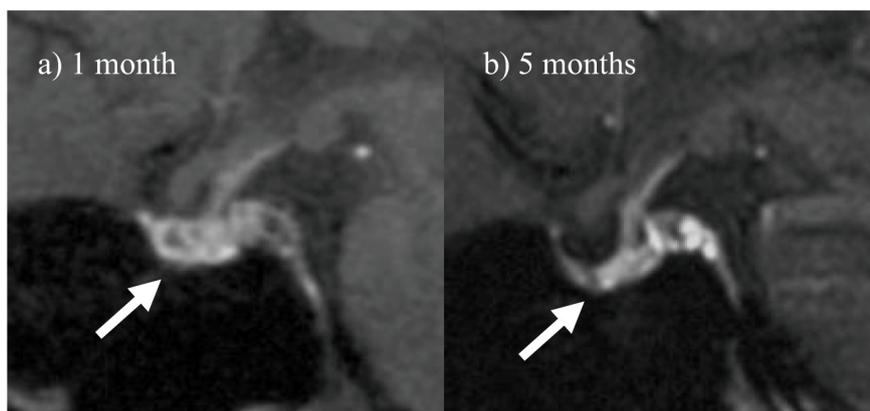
MR image in chronic phase (contrast-enhanced images)
